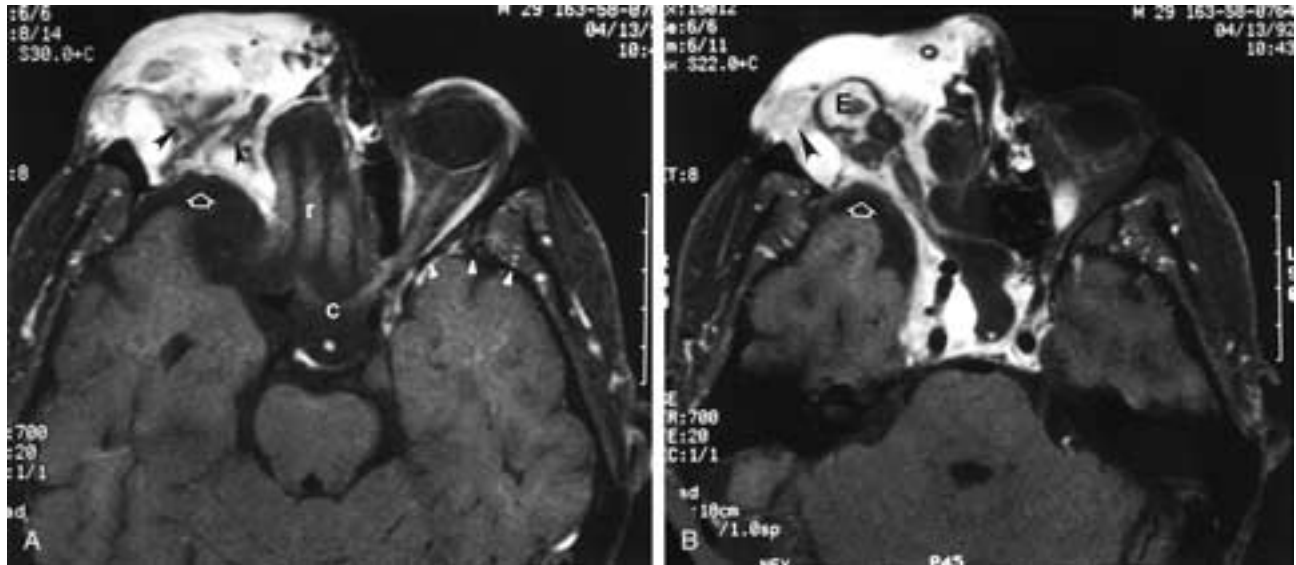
A, Neurofibromatosis with an orbital encephalocele and a plexiform neurofibroma. The abnormal neurofibroma (*arrowheads*) is seen within the malformed orbit. There is also a defect in the sphenoid bone, with herniation of the CSF space (*open arrow*) into the posterior orbit. *r*, Gyrus rectus; *c*, chiasm. Note the normal position of the anterior wall of the middle cranial fossa (*small white arrowheads*) on the opposite side. B, Axial postcontrast T1-weighted images after fat suppression. A plexiform neurofibroma (*arrowhead*) is seen within the malformed orbit. A small residual eye (*E*) can be identified. At this level, the temporal lobe can be seen following the CSF space (*open arrow*) into the posterior orbit.
